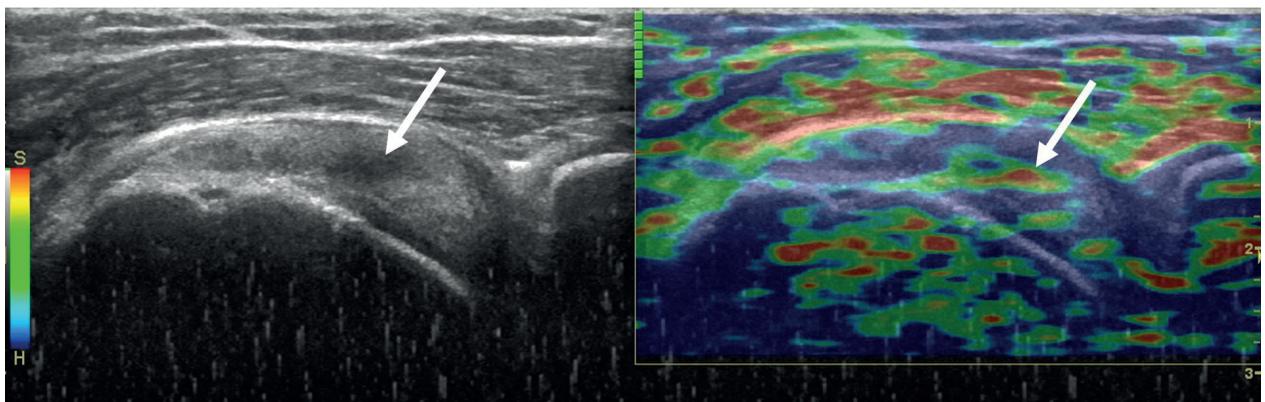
Rim-vent tear of the supraspinatus tendon (arrow). On the grey-scale ultrasound, the rim-vent tear area is hypoechoic relative to the hyperechoic normal tendon. The rim-vent tear is visualized as yellow and red areas within green on the real-time sonoelastography, indicating its intermediate to soft tissue characteristics.
